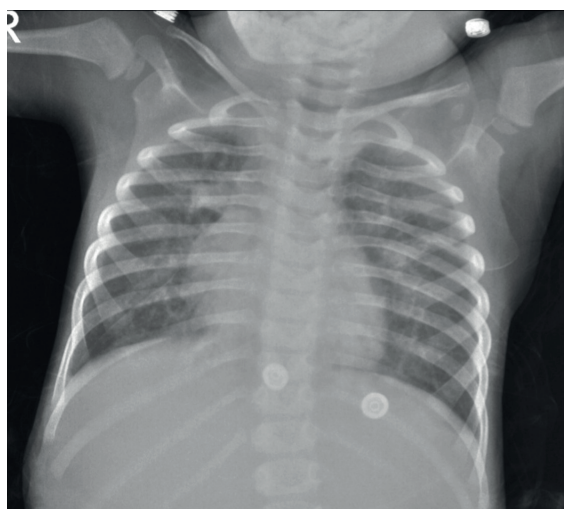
The chest X-ray shows an enlarged heart silhouette.
